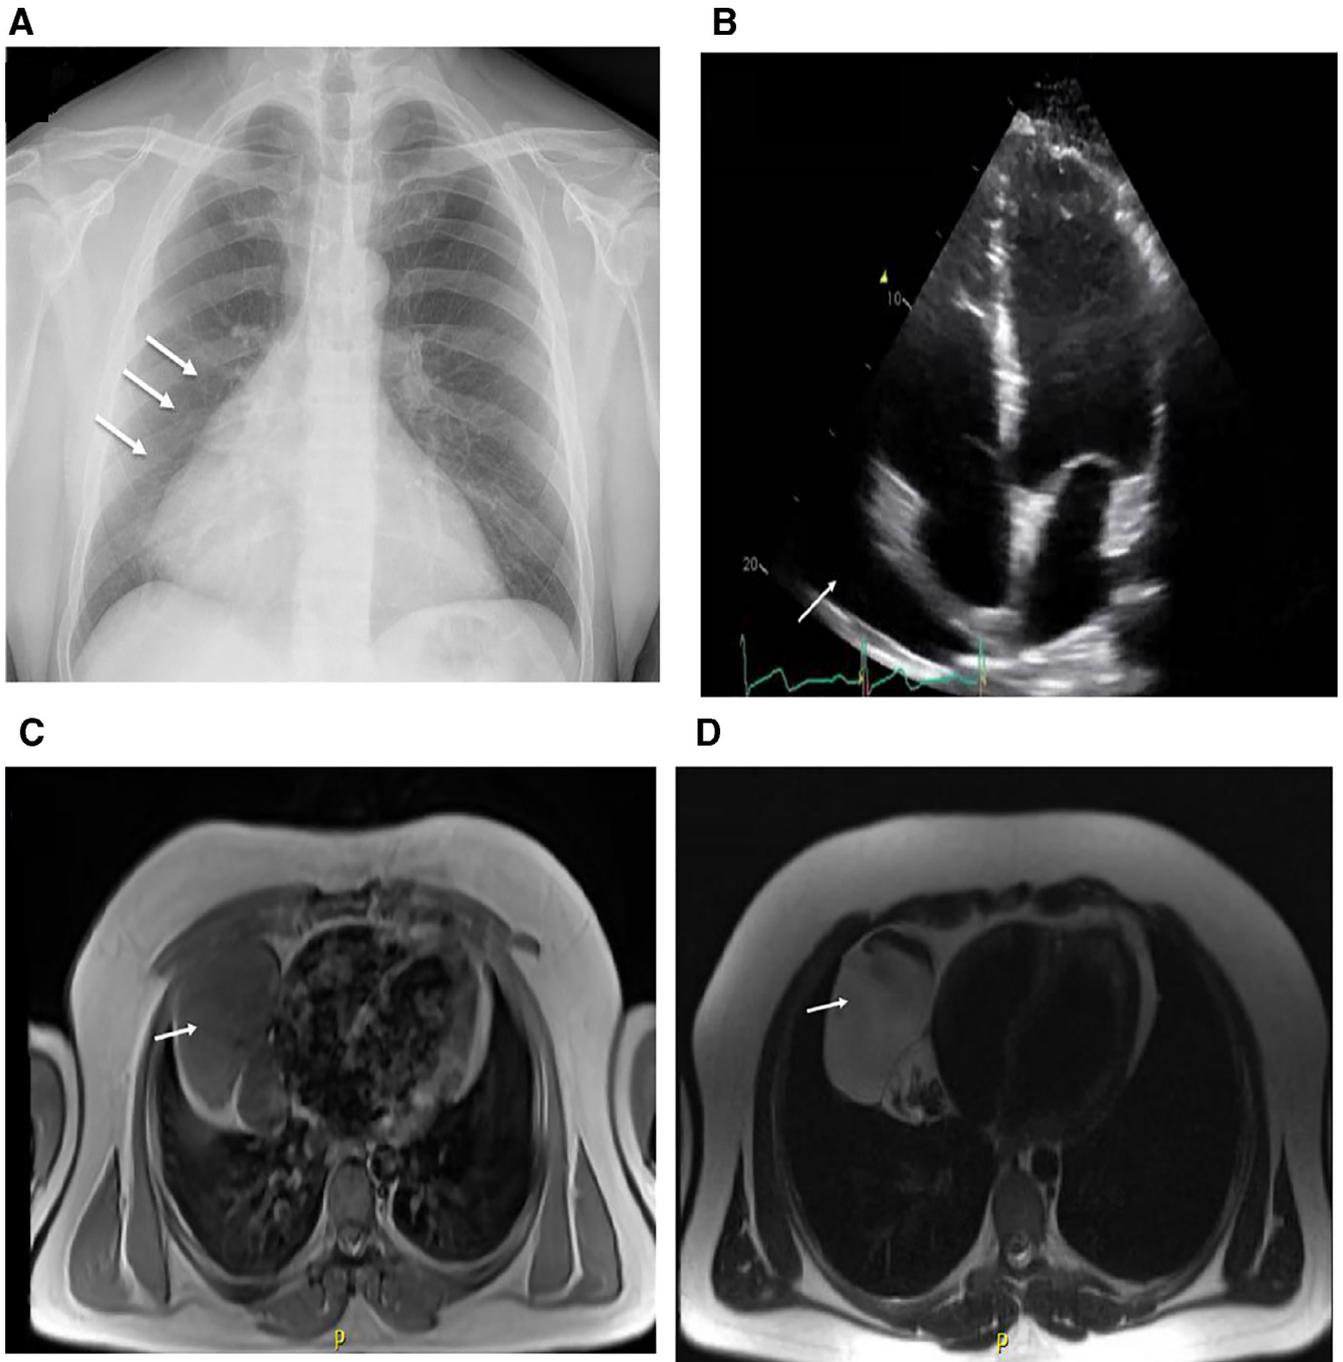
(A) Chest radiograph showing a well-circumscribed density (*white arrows*) along the right heart cardiophrenic angle (B) TTE showing the presence of an echo-lucent space (*white arrow*) adjacent to the right atrium suggesting a pericardial cyst. (C) CMR T1-weighted image showing a lobulated, low-intensity signal, cystic mass (*white arrow*) within the pericardium to the right of the right heart border. (D) CMR T2-weighted image showing a high-intensity signal of the cystic mass. CMR = cardiac magnetic resonance imaging, TTE = transthoracic echocardiography.
